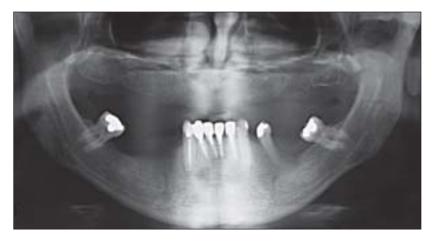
(Left) Presurgical panoramic radiograph.
